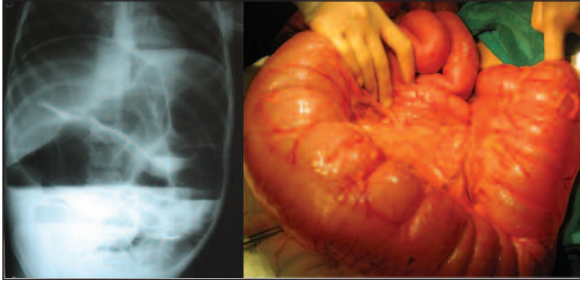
Plain abdominal X-ray and surgical findings in transverse colon volvulus.
